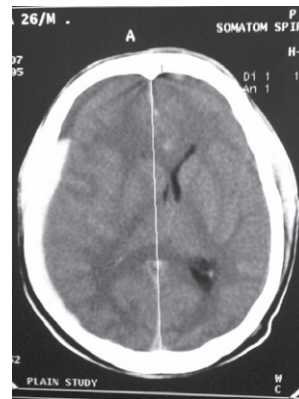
CT showing right frontoparietal subdural hematoma
